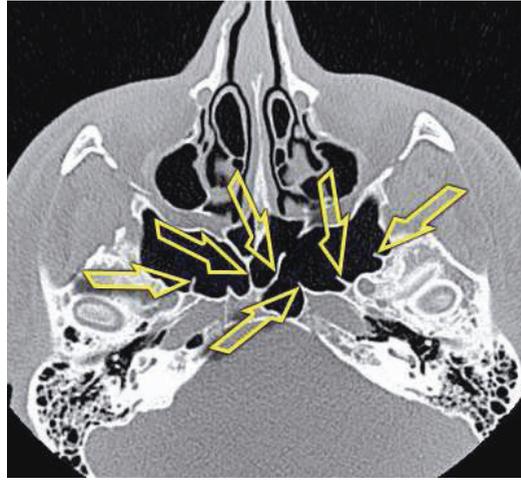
CT scan of the paranasal sinuses, transverse plane. Total number of septa — 6, total number of antra in the sphenoid sinuses — 7 (6/7).
